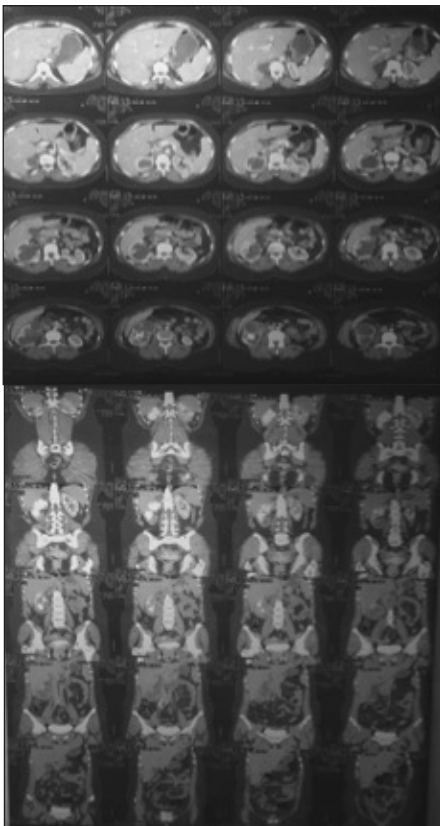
Axial and coronal cuts of CT scan before PCN insertion.
